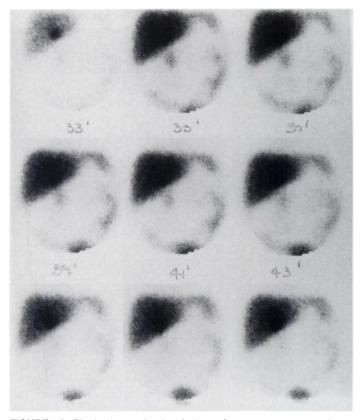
Bile leak complication 3 days after portoenterostomy in an 11-wk-old infant with biliary atresia. The SPECT scan of the abdomen shows a focal collection of tracer at the anastomosis of bowel to liver and a diffuse increase of tracer throughout the peritoneal cavity confirming a bile leak.
